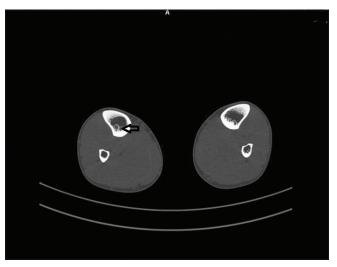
Computed tomography scan showing lytic area corresponding to tract of anomalous intratibial dilated perforating vein.
